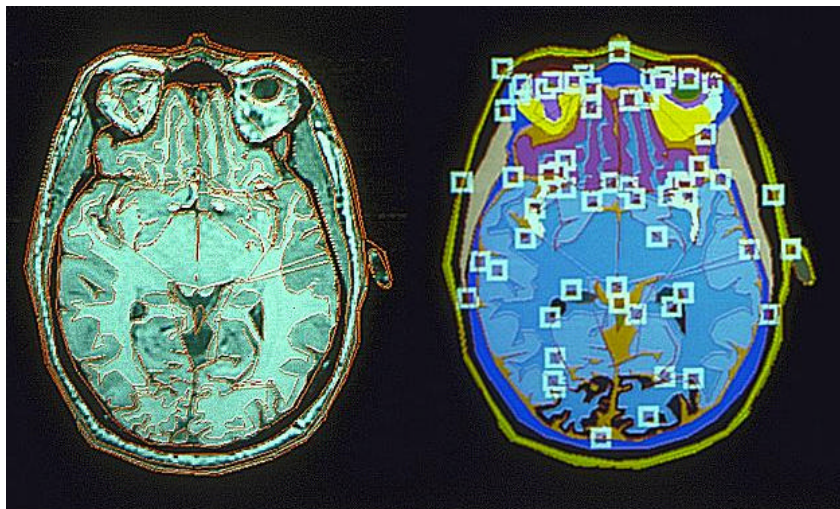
An selected original MRI T2 image with overlay of contours drawn for segmenting internal structures (left). Arbitrary color designation of internal brain structures (right); small squares are used for contour selection via screen cursor.
